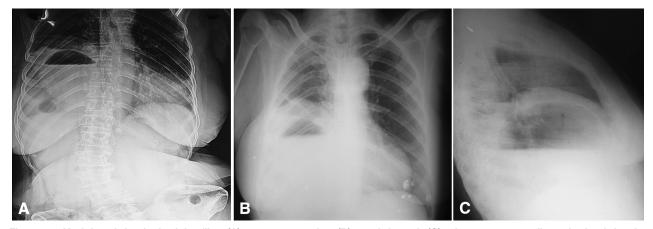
Upright abdominal plain film (A), posteroanterior (B), and lateral (C) chest x-ray studies obtained in the Emergency Department. An aberrant air-fluid level is visible at right lower hemithorax with the liver in a normal position (A, B). There is a thick radiolucent fat density encircling the air-fluid mass (B). Anterior projection of a fluid-filled gastric pouch can be seen on lateral film (C).
